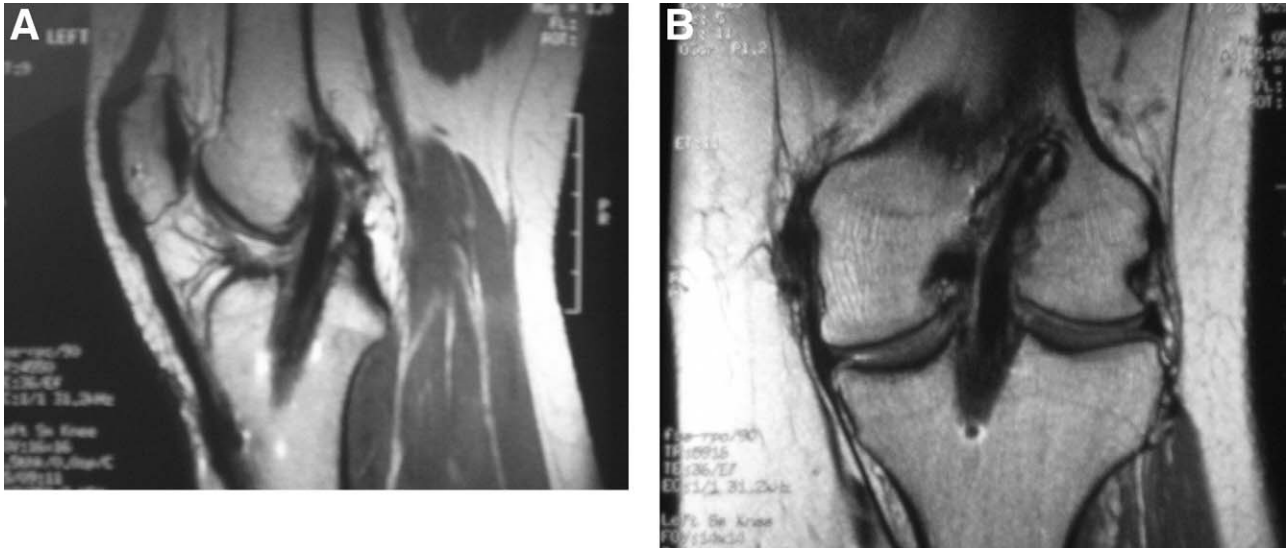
(A) Sagittal and (B) coronal magnetic resonance imaging cuts of one of our patients with a primary vertical graft who was subsequently treated with a double-bundle revision graft.
